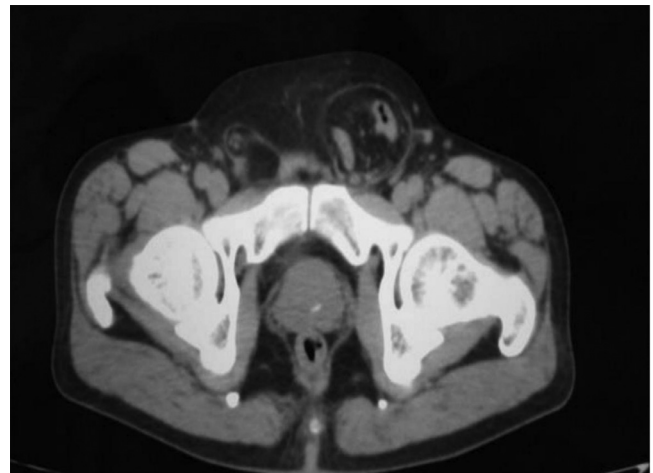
Axial plain CT images of the pelvis showing contents of the inguinal hernia (ureter, small bowel loops, omentum and fat).
